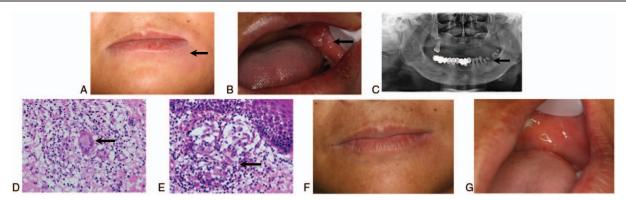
(A) The left lower lip showed diffuse edema, and the left chin skin was red with hot temperature; (B) cobblestone formation was visible on the left buccal mucosa. Note that the mandibular molars developed black residual roots; (C) residual roots were present in the mandibular molars, and x-ray shadow around roots suggested apical periodontitis; (D and E) high-power magnification demonstrated granulomatous inflammation (E, arrow) beneath the cobblestone mucosa with multinucleated giant cells (D, arrow); (F and G) the swelling and redness disappeared on the lower lip and left chin, and cobblestone formation was invisible on the left buccal mucosa after treatment.
